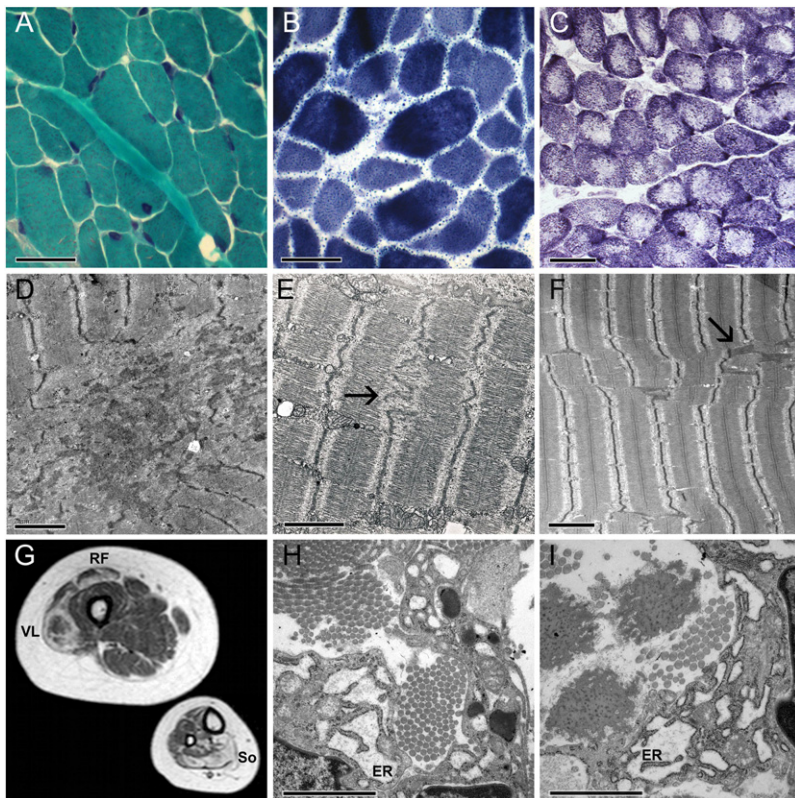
Muscle MRI, Histomorphology, and Ultrastructure of Muscle and Skin
